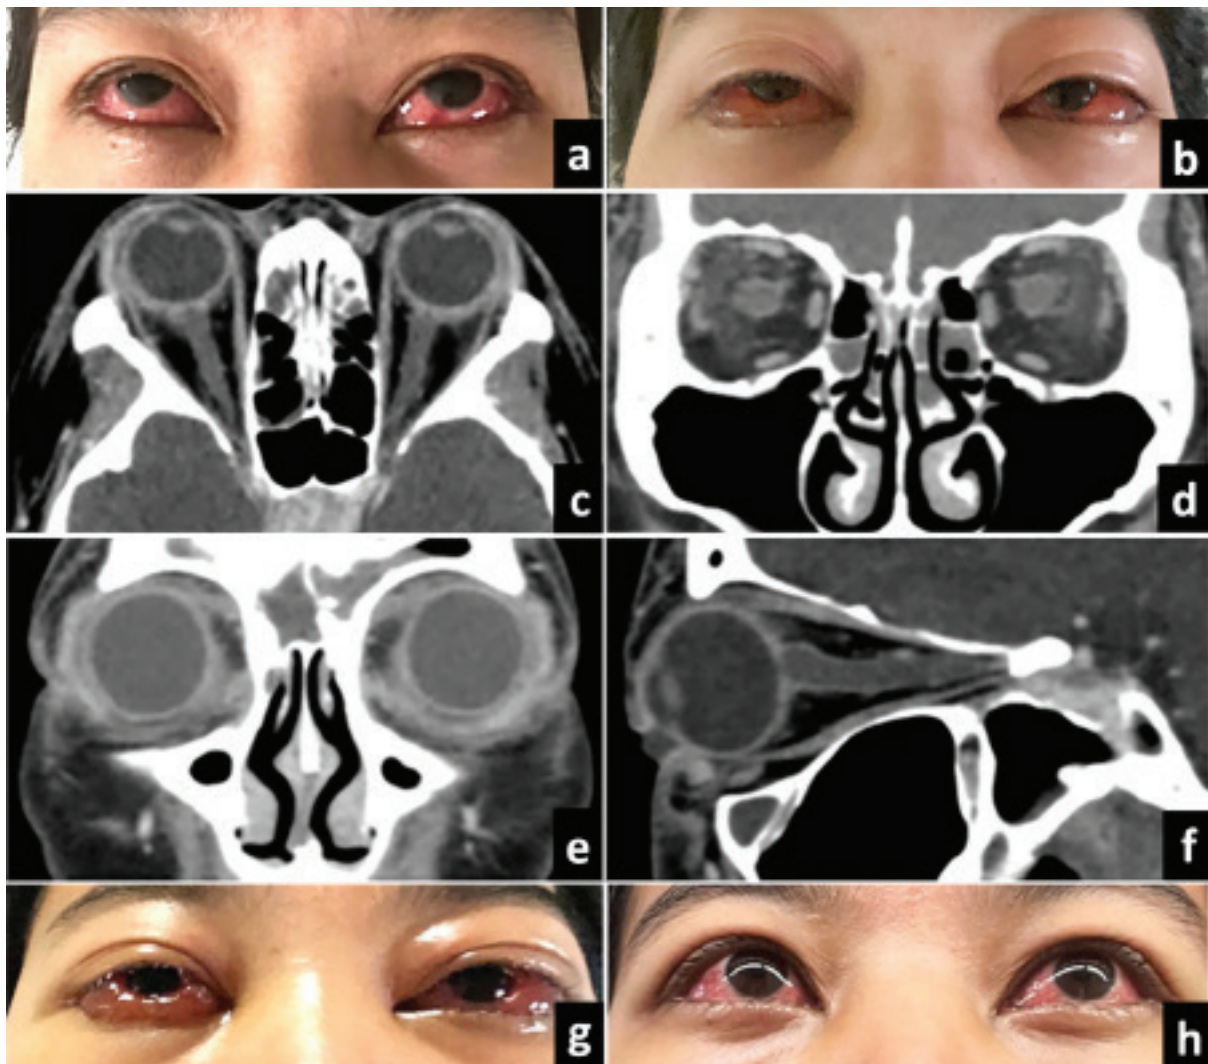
(a) Bilateral, moderate, diffuse conjunctival injection observed 6 days after the onset of systemic COVID-19 symptoms. (b) Bilateral periorbital edema and massive chemosis at the initial ophthalmological examination (day 11 of illness). (c-f) CT images with contrast show bilateral proptosis with diffuse scleral thickening, diffuse infiltration of periorbital and retrobulbar fat, prominent bilateral lacrimal glands and partial opacification of both frontal sinuses. (g) Follow-up clinical examination 48 hours after systemic antibiotic therapy did not reveal a clinical response. (h) There was significant improvement in periorbital edema, chemosis, and proptosis at 48 hours after starting systemic corticosteroid treatment.
